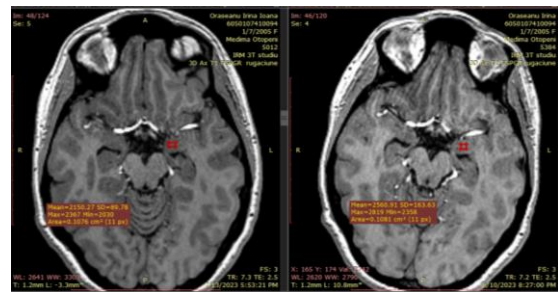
The right side of the amygdala seen from the MRI results
